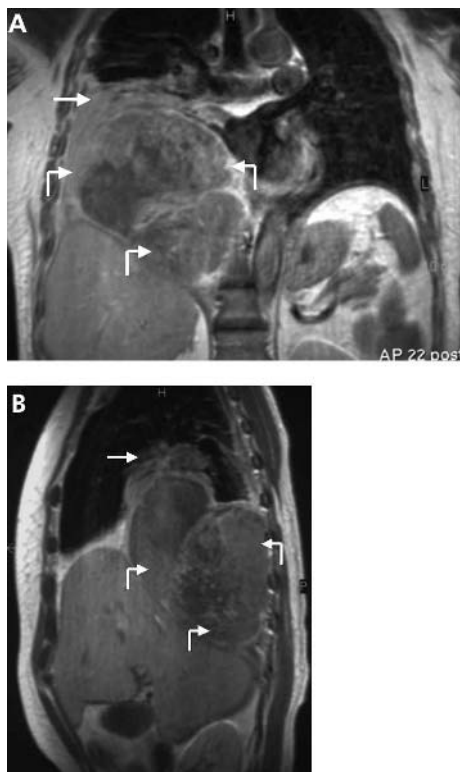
(A) T1-weighted coronal and (B) sagittal MR images showing a heterogeneous mass in the right lower hemithorax (curved arrows) associated with compression and displacement of the right lower lobe (straight arrow) and right hemidiaphragm.
